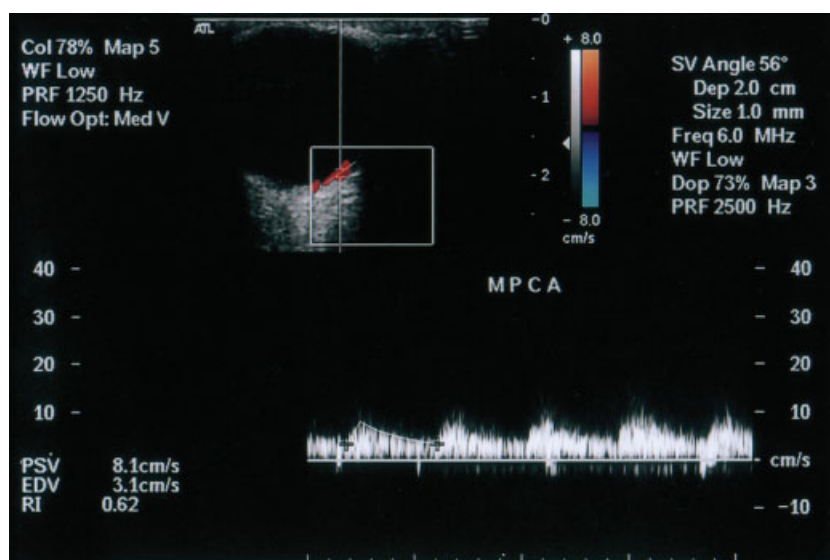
Color duplex sonogram of a medial posterior ciliary artery (MPCA) in a patient with obstructive sleep apnea syndrome shows a peak systolic velocity (PSV) of 8.1 cm/second and a resistance index (RI) of 0.62.
